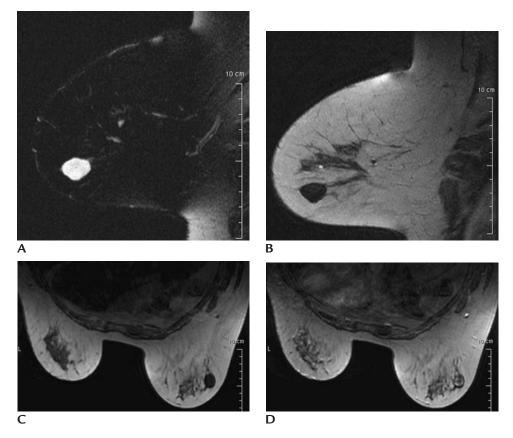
Fibroadenoma. Magnetic resonance imaging. (A) Sagittal T2-weighted, fat suppressed image. Oval mass with bright signal intensity. As estrogenic stimulation decreases and epithelial elements atrophy, the signal intensity on T2-weighted images usually decreases. (B) Sagittal T1-weighted image. Mass, low signal intensity. (C) Axial pre-contrast T1-weighted image. Oval mass in the right breast, low signal intensity. (D) Axial T1-weighted image one minute post contrast. Heterogeneous enhancement with internal non-enhancing septations. Low signal intensity from rim of lesion. Did you notice the regional stippled enhancement laterally in the left breast? Patient with invasive ductal carcinoma, left breast.
